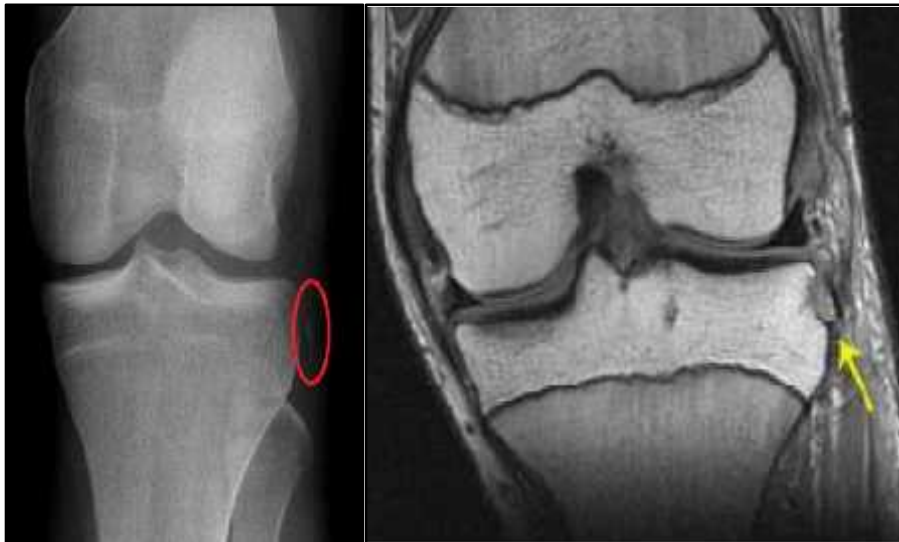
SEGOND'S FRACTURE IN X-RAY AND MRI
